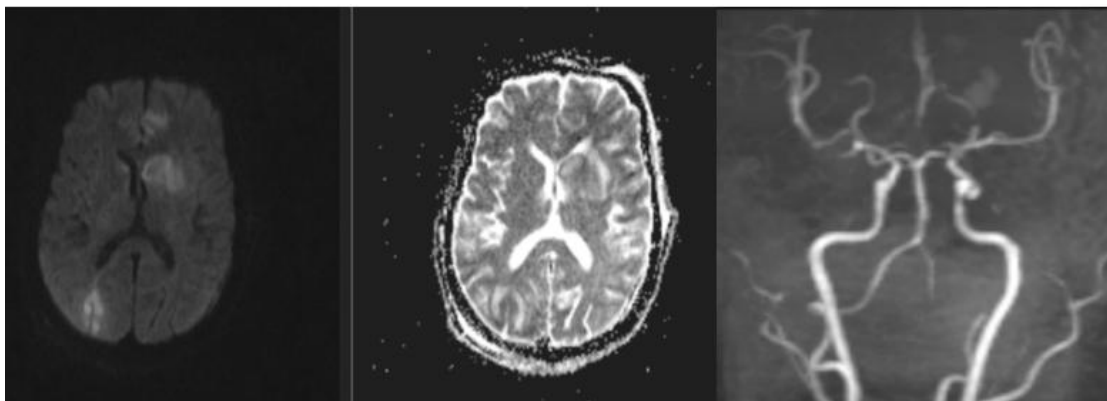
MRI Brain on 27/04/2026 – Axial sections of DWi and ADC sequence reveal focal restriction diffusion in the supratentorial neuroparenchyma. MRI Brain angiography coronal section appears normal.
